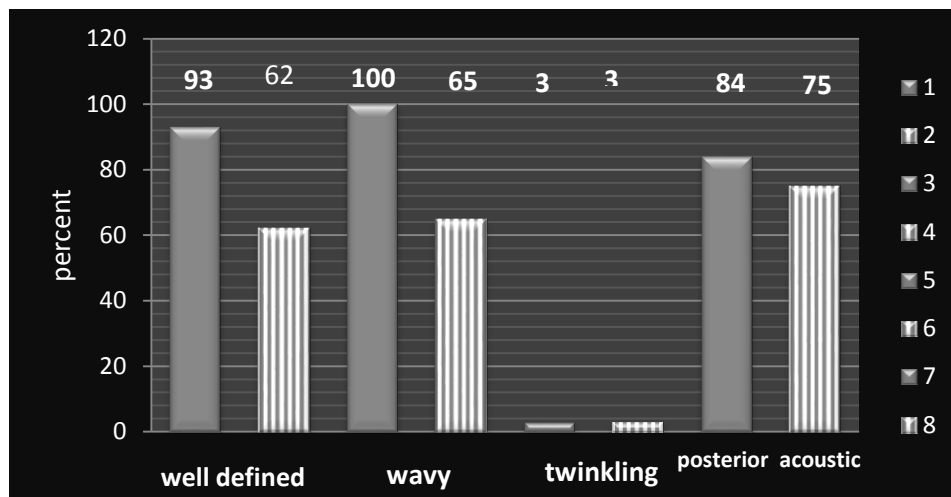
Ultrasonographic characters of mesh. Solid columns represent laparoscopic repair while shaded columns represent open surgical approach
